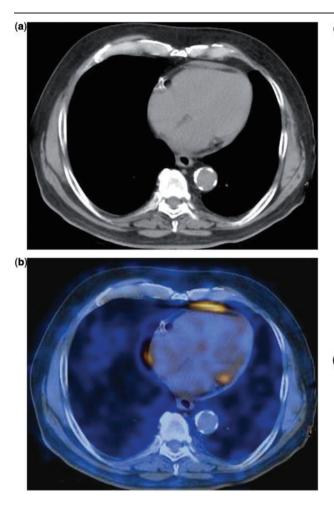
A 59-year-old man with lung cancer. (a) CT demonstrates pericardial thickening. (b) PET/CT reveals increased FDG uptake, indicating that metastatic cancer is the cause of this thickening.
